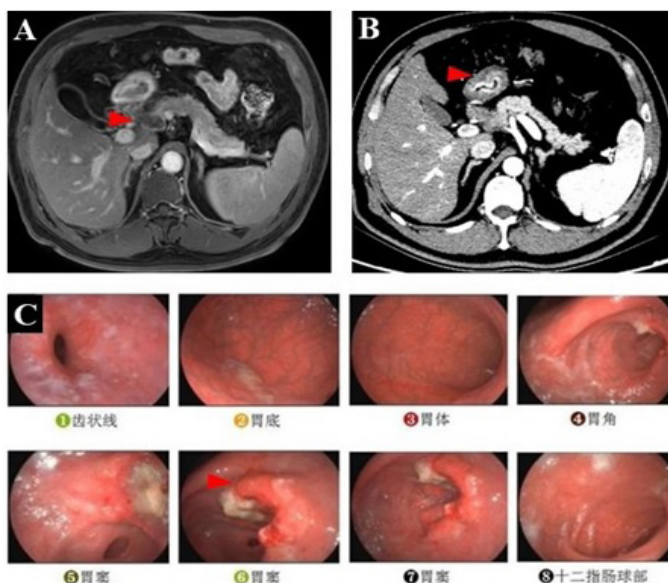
Imaging before laparoscopic exploration. (A) MRI showed a nodule measuring 3.9cm×1.5cm was above the head of pancreas. (B) CT detected diffuse thickening of gastric antrum. (C) Gastroduodenoscopy indicated gastric antral cancer, and the Borrmann classification was type III.
